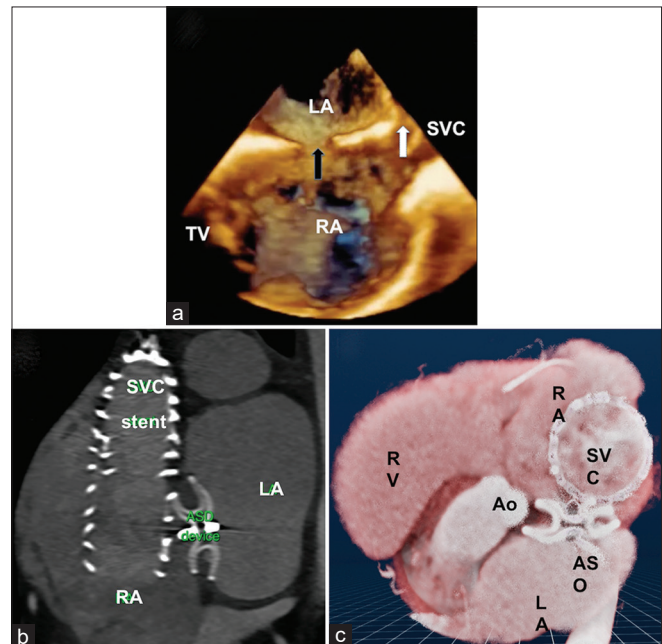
Bicausal view of three-dimensional transesophageal echocardiography (a) shows oval fossa defect (black arrow) and superior vena cava (SVC) straddling a sinus venosus defect (white arrow) between the left atrium and right atrium. Six months after combined intervention with a covered stent deployment in SVC and atrial septal occluder device, sagittal slice (b), and color-rendered computed tomography (c) images demonstrate the anatomy. SVC: Superior vena cava, RA: Right atrium, LA: Left atrium, RV: Right ventricle, TV: Tricuspid valve, ASD: Atrial septal defect
